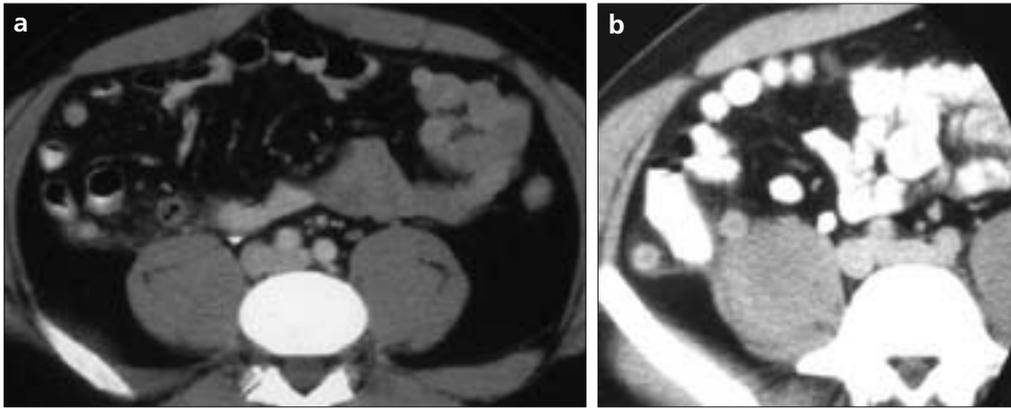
a, b. Axial CT images of two different cases showing a thickened appendix wall with homogenous enhancement after intravenous contrast medium administration.
